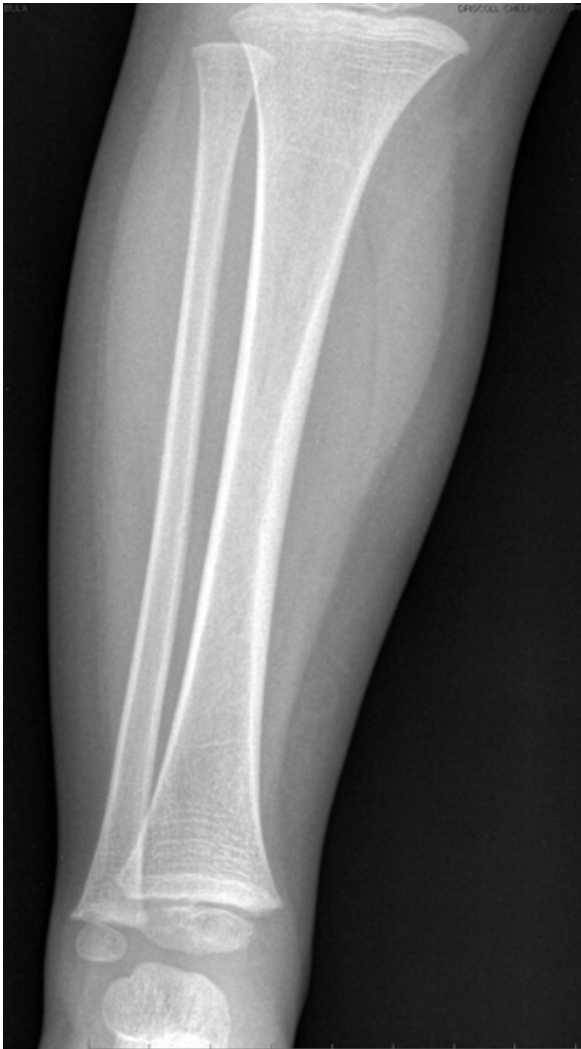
26-month-old boy with limp. AP radiograph of right tibia and fibula is normal.
